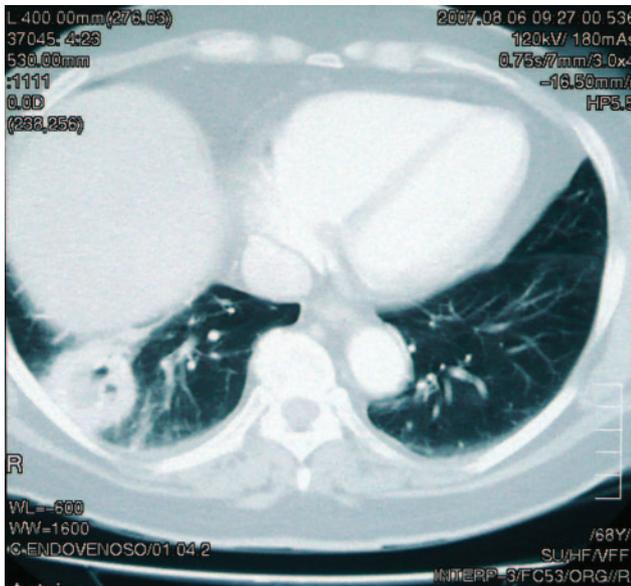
Thoracic computed tomography. There is a 4 cm cavitory lesion in the lower right lobe.
